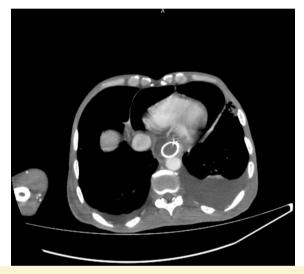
CT thoracic-sectional images of pneumopericardium surrounding the heart. CT, computed tomography.
